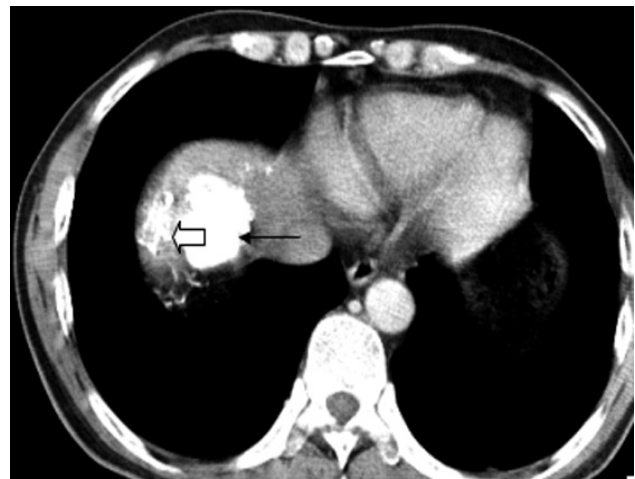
Lung uptake: nonenhanced CT scan obtained 28 days after chemoembolization shows hyperattenuating ethiodized oil (white arrow) in the lower lobe of the right lung beside ethiodized oil in hepatocellular tumor (black arrow).
